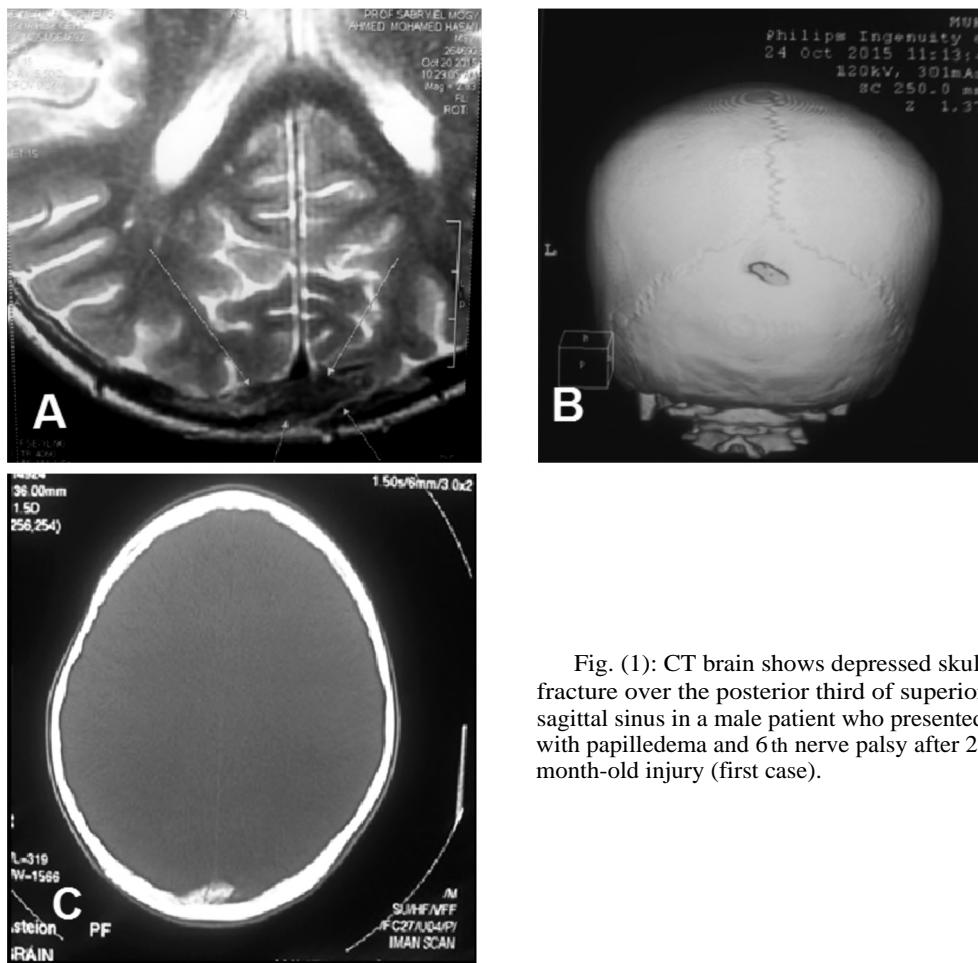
CT brain shows depressed skull fracture over the posterior third of superior sagittal sinus in a male patient who presented with papilledema and 6th nerve palsy after 2-month-old injury (first case).
